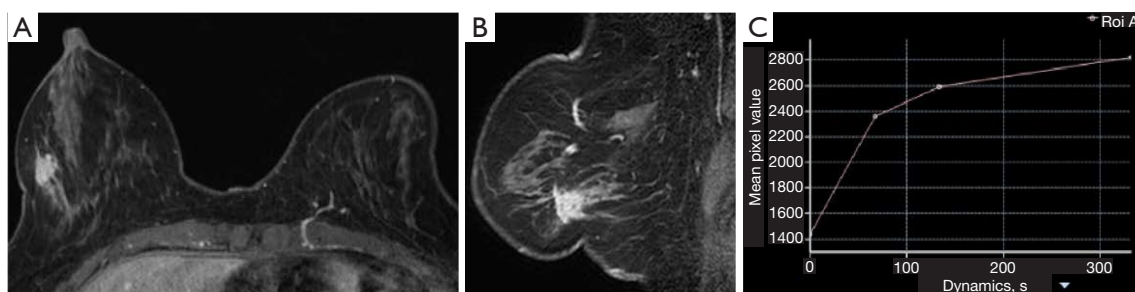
Preoperative MRI findings. (A) MRI with early gadolinium enhancement coronal section. (B) MRI with early gadolinium enhancement in the sagittal section. (C) Time-intensity curve. An enhanced 22-mm mass was observed in the right breast area. The time-intensity curve was fast-plateaued. MRI, magnetic resonance imaging; RoiA, region of interest analysis.
